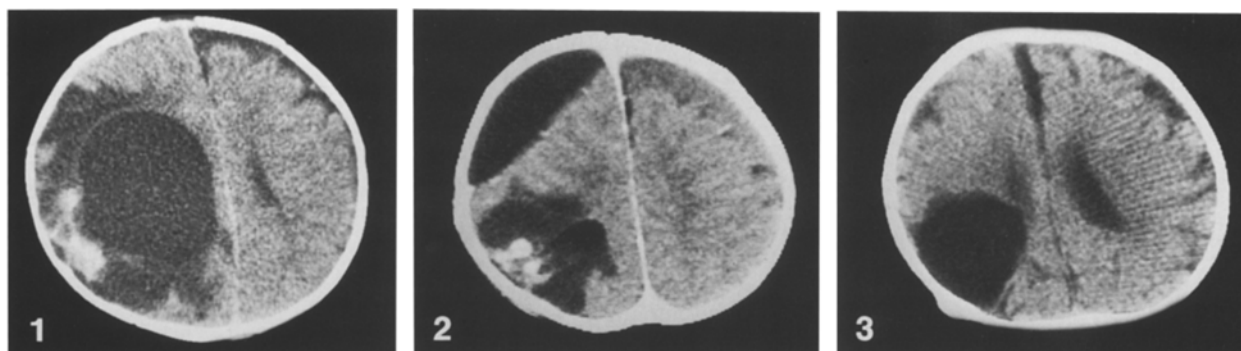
Preoperative CT scan on 14 October 1987, showing a large cystic mass with contrast-enhancing lesions in the cortical surface
